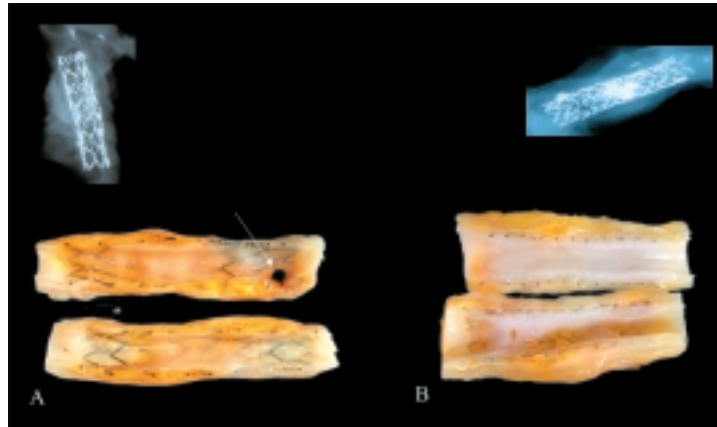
A: post-mortem autoradiography and gross appearance of the 16-month-old left anterior descending coronary artery sirolimus Bx Velocity stent. The gross photograph of the longitudinally cut sirolimus-eluting stent shows a translucent neointima with the stent struts barely visible. A minute thrombus (arrow) was present at the distal end of the stent, near the ostium of a small side branch. B: post-mortem radiography and gross appearance of the 24-month-old right coronary artery Multi-Link™ stent. Gross photograph of the longitudinally cut Multi-Link™ stent showing an opaque neointimal appearance and no stent struts visible. Reprinted from Guagliumi et al.¹⁴, with permission.
